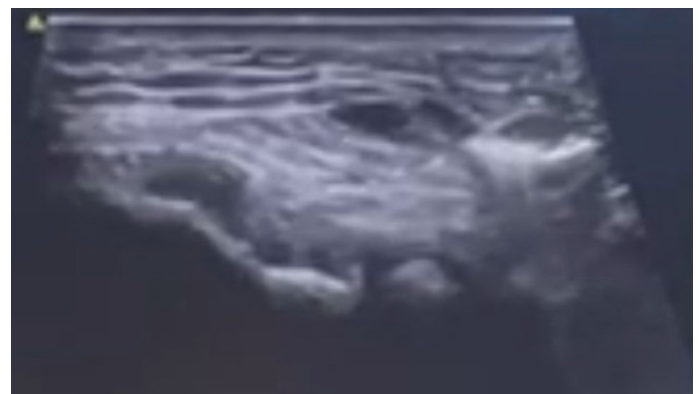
Steroid and lignocaine Mixture Injection given below the common extensor tendon(Ultrasound guided)
